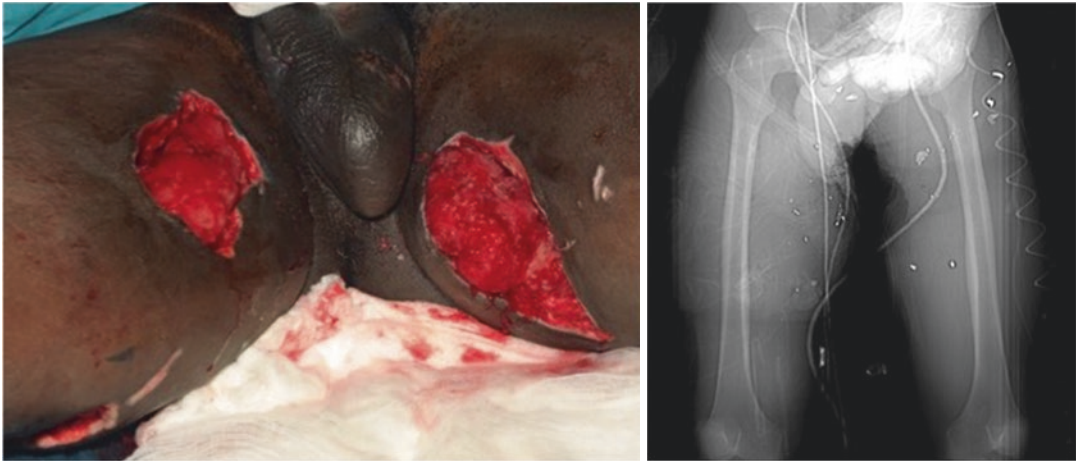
Clinical photograph taken 2-days post-injury and CT scout view showing a GSW to bilateral thighs. The wound was caused by a military 5.56 mm SS109
